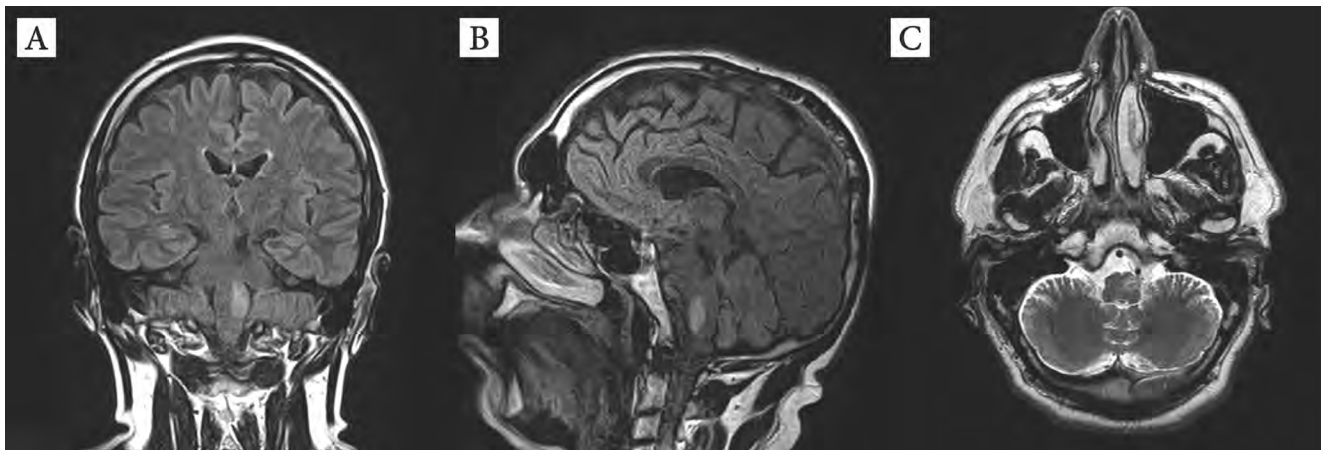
Brain MRI performed 18-months after the brainstem haemorrhage showing similar aspect with the MRI performed two months before.
